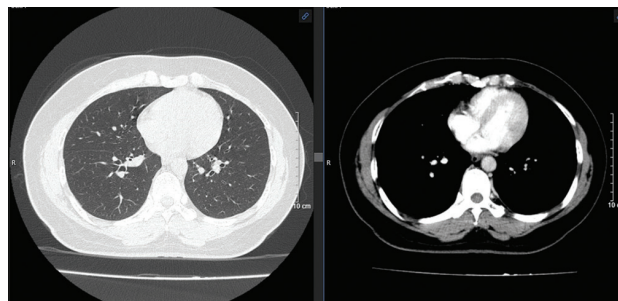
Contrast-enhanced thoracic computed tomography demonstrating normal thoracic anatomy with no radiological evidence of metastatic disease. The bilateral lung parenchyma demonstrates a homogeneous appearance, with no evidence of either focal or diffuse pulmonary lesions (left). The mediastinal structures are well-aligned and symmetrical. The chest wall, including the bony structures and surrounding soft tissues, shows no abnormal findings (right).
